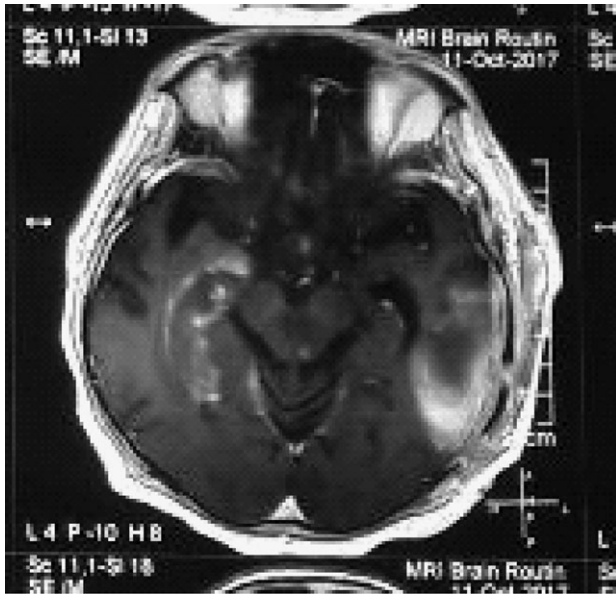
MRI at 6weeks: persistent lesion in left temporal lobe with appearance of new lesion in right hippocampal and mid brain area.
